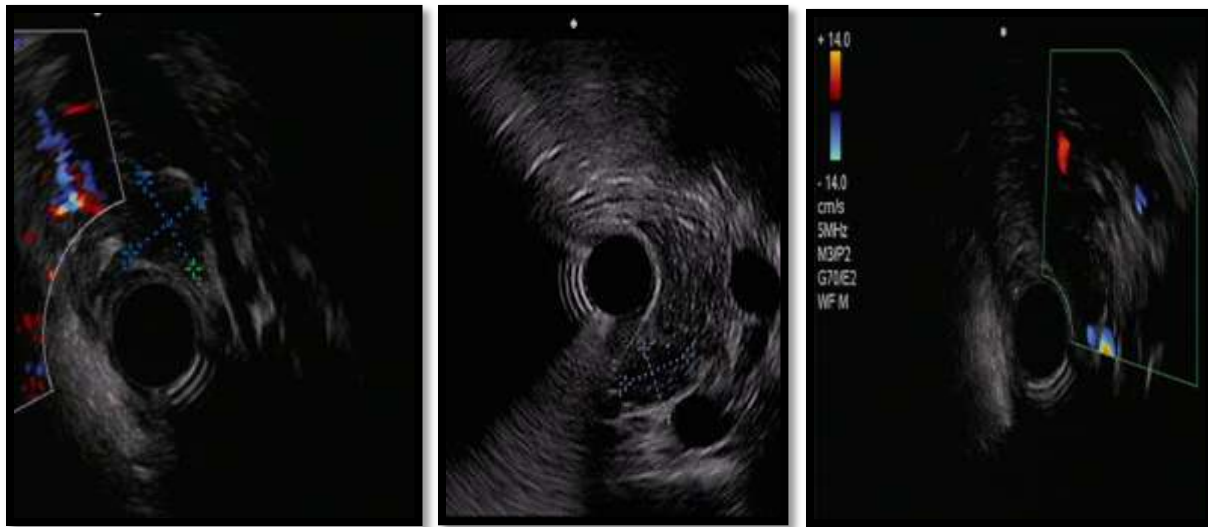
Endoscopic ultrasound (EUS) : hypoechoic lesion of the pancreatic body.
